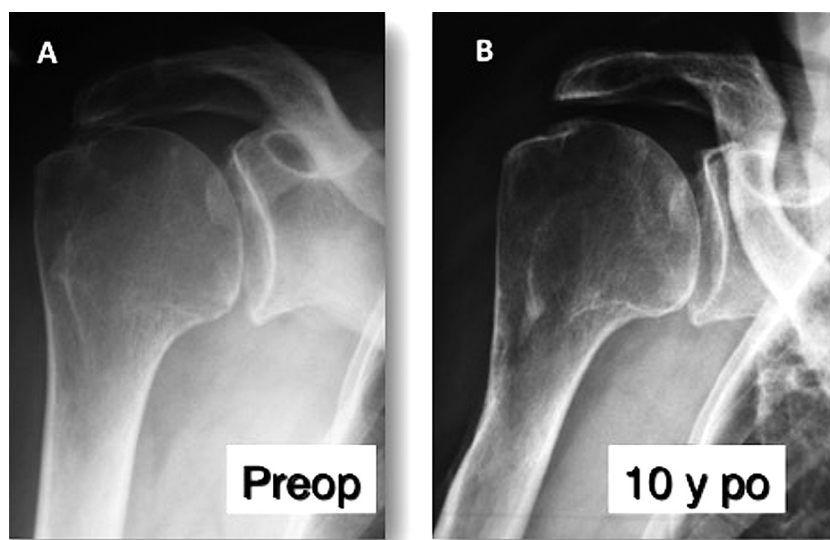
Radiographic evolution 10 years after modified L'Episcopo tendon transfer (same patient as in Fig. 6). (A) Preoperative cuff tear arthritis Hamada stage 2. (B) Anteroposterior radiograph taken 10 years after surgery does not demonstrate major change. Notice the footprint of the LD/TM transfer on the lateral aspect of the humerus.
